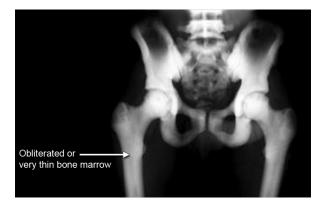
X-ray of osteopetrotic bone
